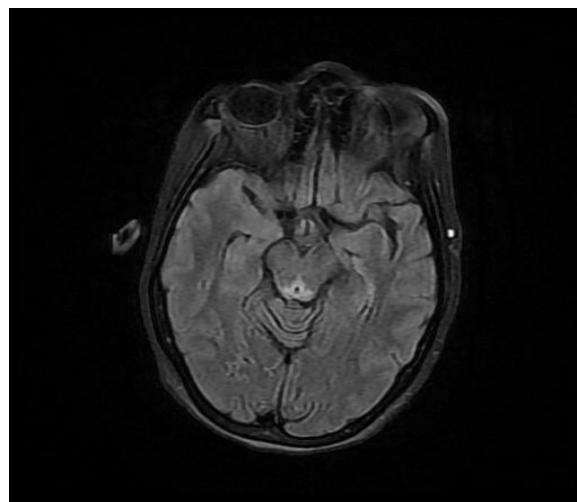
FLAIR hyperintensity in the periaqueductal region
